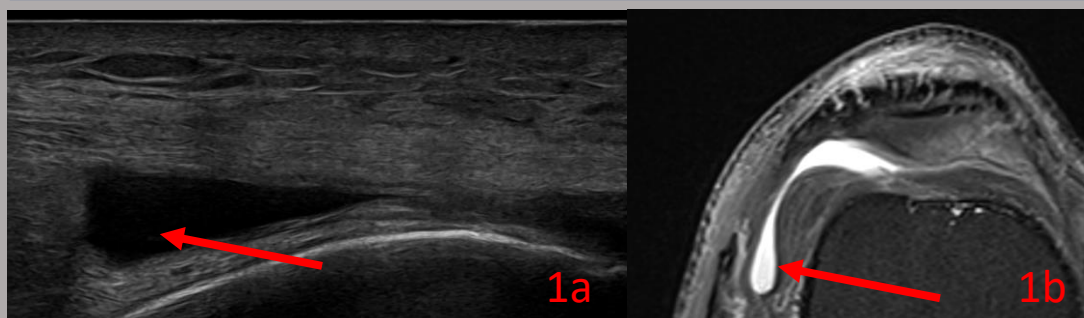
(above) - The knee joint capsule is a potential space; this can become distended with fluid and present as knee swelling/ lump. The fluid is most commonly seen in the suprapatellar 'pouch' (see figure 2 for explanation of anatomical terminology). This space has recesses laterally and medially where fluid will settle dependently (arrow in (a) - transverse US and (b) - axial PDFS MRI). Unless the volume of effusion is significant and 'tense', the fluid may be fluctuant and able to be manipulated. Please note that joint fluid is not the only source of effusion, which can contain blood or fat, depending on aetiology.
